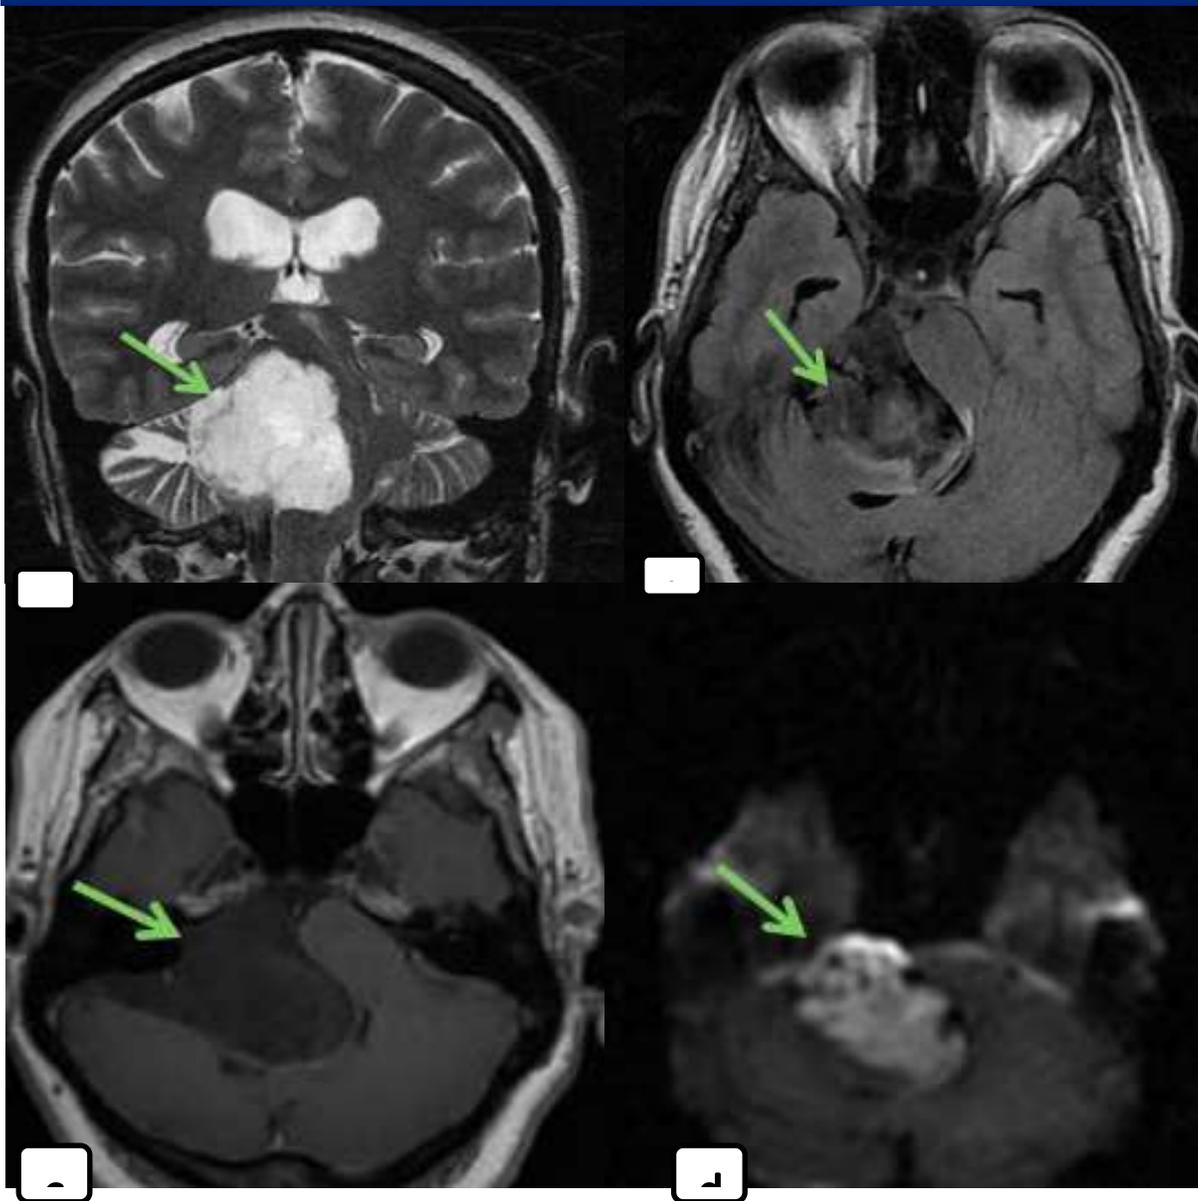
MRI in coronal section in T2 sequences (a); in axial section in FLAIR sequence (b); in axial section in T1 injected sequence (c) and in Diffusion sequence (d): Lobulated mass, extra axial, occupying the right cerebellar ponto angle, hypointense in T1, hyperintense in T2 with diffusion restriction and not showing enhancement after contrast agent injection. Repression and compression of the brainstem, right cerebellum and fourth ventricle with moderate passive upstream hydrocephalus. →Epidermoid cyst
